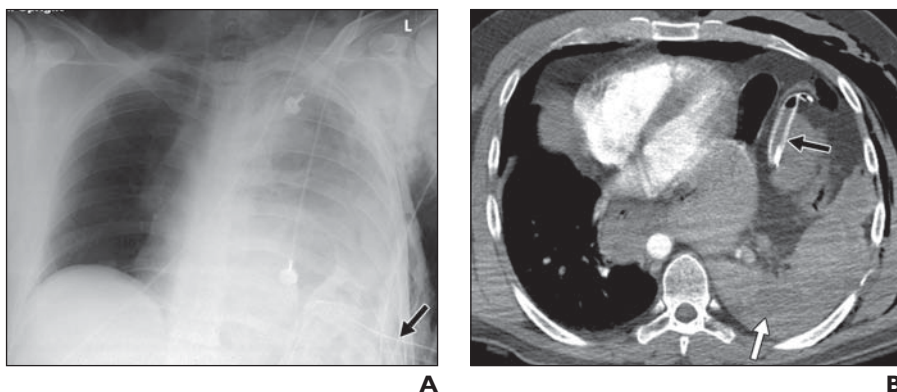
30-year-old male victim of motor vehicle trauma with abdominal placement of chest tube. A, Anteroposterior chest radiograph shows horizontally oriented chest tube (*arrow*) in left lower hemithorax. There are several left rib fractures, opacification of left hemithorax, and subcutaneous emphysema. B, CT image shows traumatic left diaphragmatic rupture with migration of abdominal content to left hemithorax. Chest tube (*black arrow*) is seen within mesenteric fat abutting small bowel loops. Note splenic rupture (*white arrow*) related to trauma.
